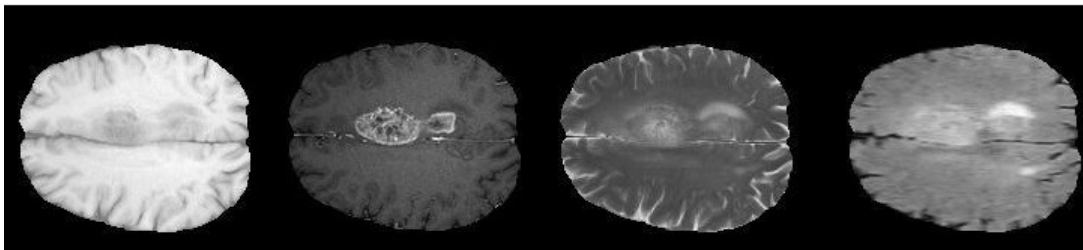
T1, T1 Contrast, T2 and FLAIR MRI of a Tumour Affected Brain
